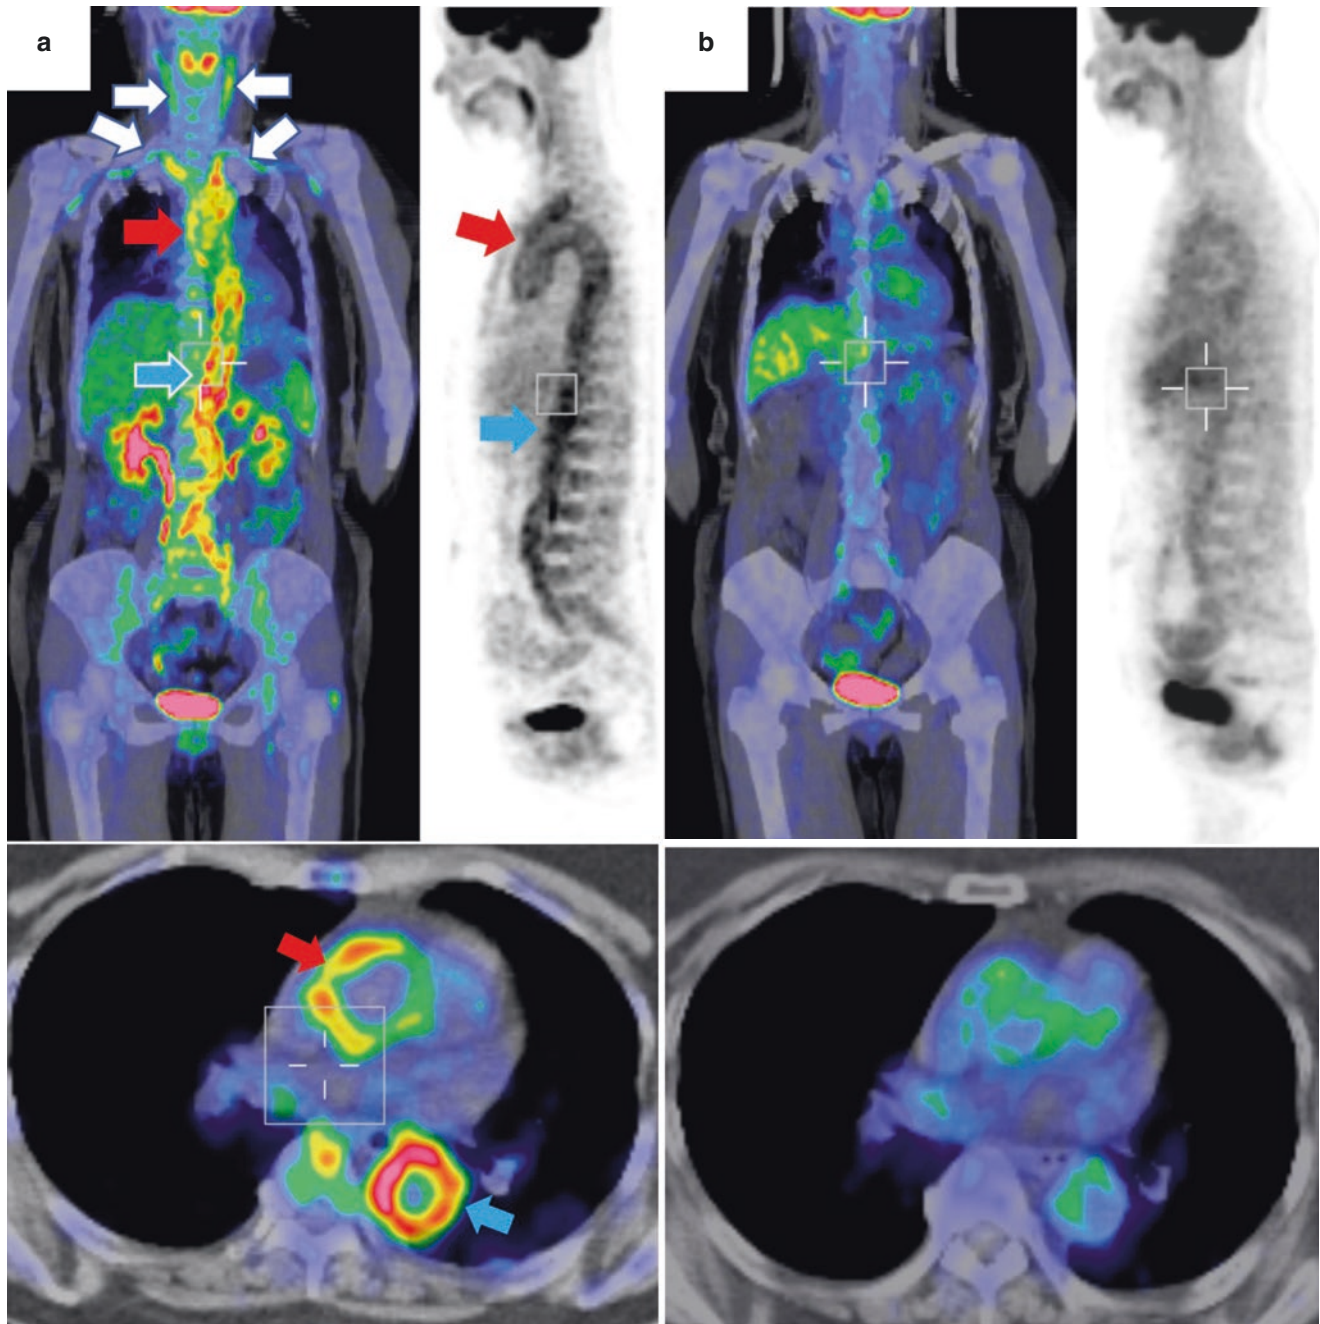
Takayasu arteritis in a 62-year-old female patient. (a) FDG-PET/CT (coronal and axial slices) and PET (sagittal slice) images before treatment. High accumulation of FDG in the subclavian and carotid arteries (white arrows on coronal view) and the ascending (red
